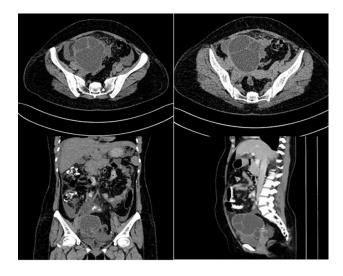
Axial and coronal views of contrast enhanced computed tomography of the abdomen showing a well-defined smooth-walled (maximum wall thickness approximately cystic lesion of 94×88 mm in the pelvis.
